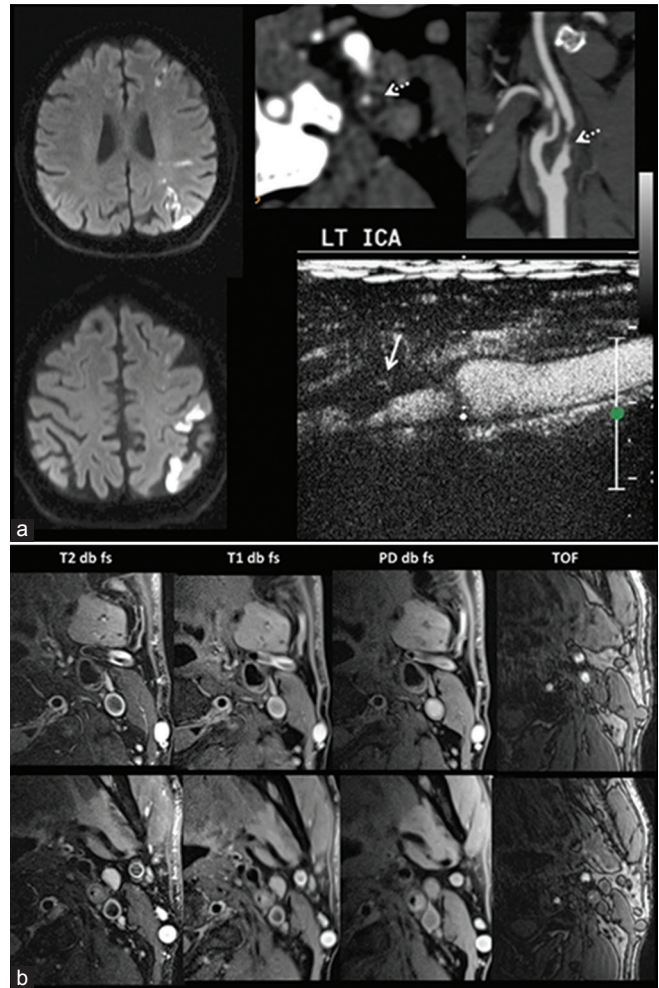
A 67-year-old male with left middle cerebral artery and middle cerebral artery-anterior cerebral artery watershed territory stroke. On computed tomography angiography (a), left internal carotid artery 80% stenosis. Plaque has attenuation of 37.6 HU. A Type 3 ulceration is present (dotted white arrows). On contrast-enhanced ultrasound, plaque neovascularization is seen with surface irregularity. On magnetic resonance imaging plaque imaging (b), plaque appears isointense on proton density and hypointense to isointense on T2-weighted. It is mildly hyperintense on T1-weighted and isointense on time-of-flight images s/o fibrofatty plaque. Surface ulceration is present
